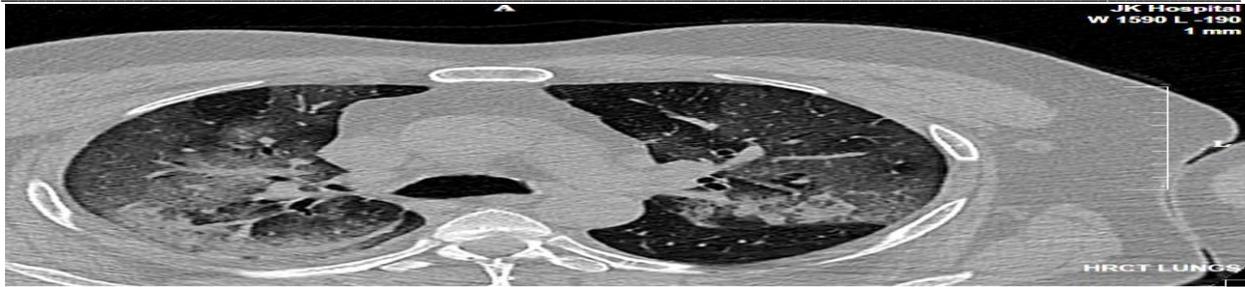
HRCT of co-morbid patient (DM with HTN) showing multiple confluent patches of GGO with minimal Pleural effusion along right oblique fissure. CT severity score; 28-30 (Severe lung involvement).
